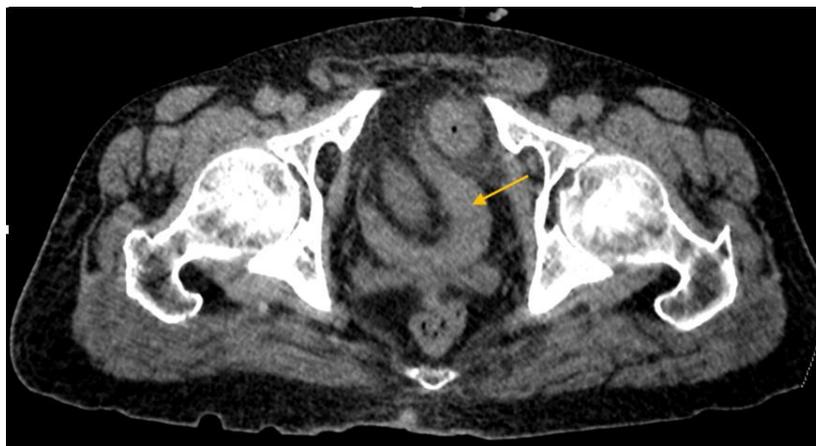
Abdominal CT scan reveals an obstruction of the small intestine with distension of the small bowel loops resulting from hydroaeric levels
